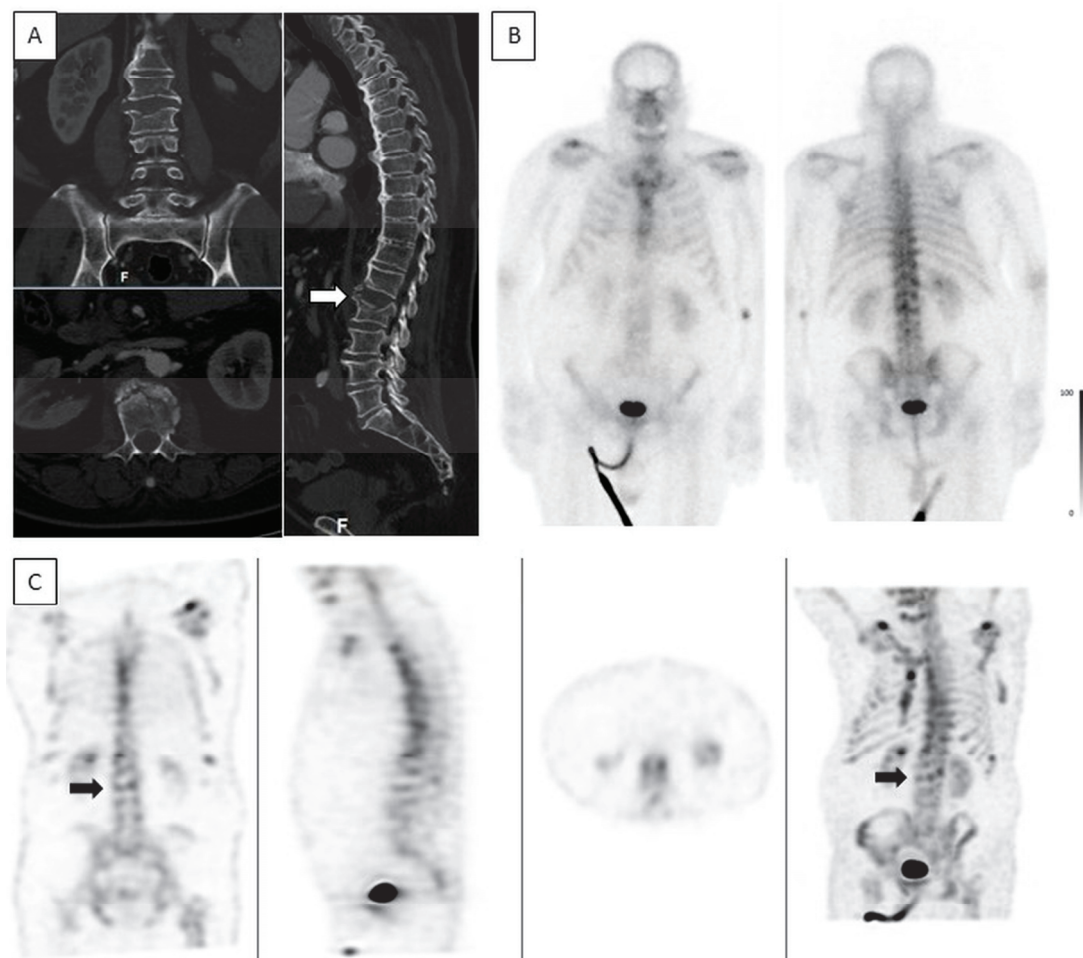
Low-intensity uptake in an acute ankylotic VCF. A 72-year-old male. CT was acquired on the day of injury and bone scintigraphy was performed 3 days after the injury. (A)—Coronal, axial, and sagittal spine CT show an acute ankylotic fracture in L2 and a fracture involving an osteophyte in L1 (white arrow). (B)—Planar anterior and posterior bone scintigraphy do not show any increased uptake in L2. (C)—Coronal, sagittal, axial, and MIP SPECT show only low-intensity uptake in L2 (black arrow).
